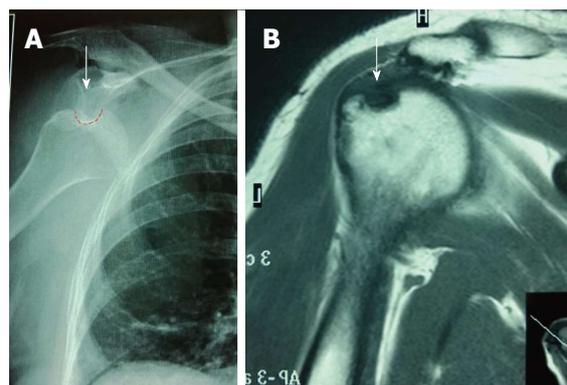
Engaging Hill-Sachs lesion leading to recurrent anterior instability (A) and Hill-Sachs lesion on magnetic resonance imaging (B).
